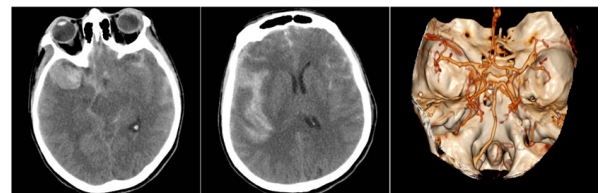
a,b - Axial noncontrast-enhanced computed tomography (CT) shows shows localized right intracerebral temporopolar hematoma aneurysmal origin with significant brain edema, c - CT angiography shows ruptured aneurysma of right middle cerebral artery (MCA) (Department of Radiology, Clinical Center University of Sarajevo, 2016)
